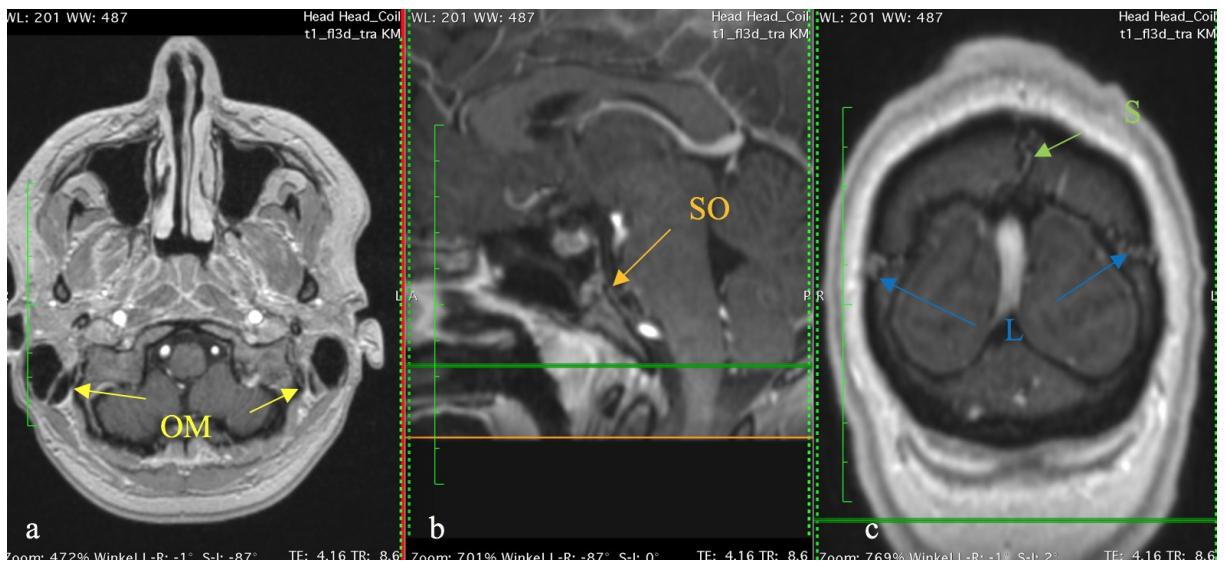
Cranial MRI of a 16 years old male in a axial view, b sagittal and c coronal reformat (yellow arrows: left and right occipitomastoid suture, orange arrow: sphenoccipital suture, green arrow: sagittal suture, blue arrows: left and right lambdoid suture).
